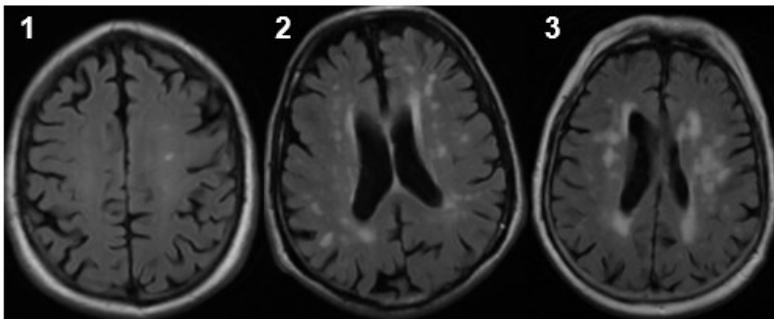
Axial FLAIR images showing examples of the grading of white matter hyperintensities using the Fazekas scale. Examples are presented for scores 1-3 for (A) periventricular white matter hyperintensities (B) deep white matter hyperintensities.
